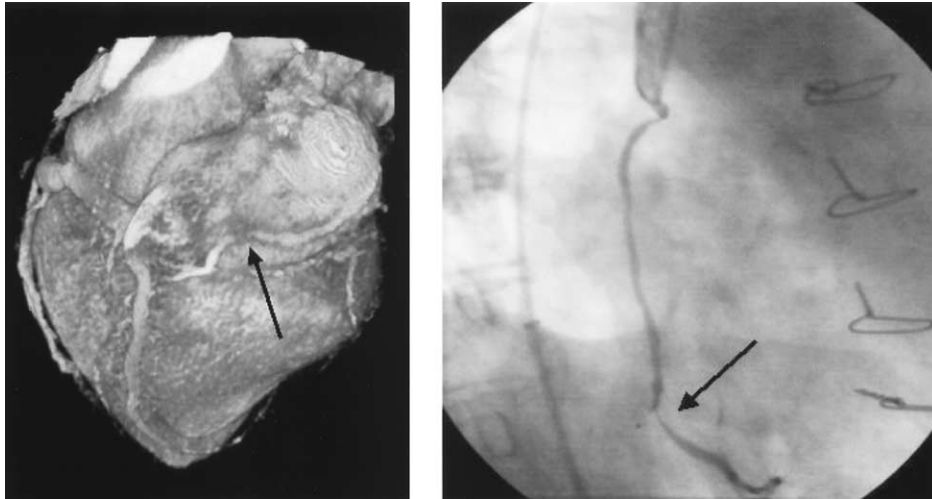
Three-dimensional multislice spiral computed tomography reconstruction (volume rendering) of a venous graft to the right coronary artery with a hemodynamically relevant stenosis (left) that was confirmed by invasive coronary angiography (right).
